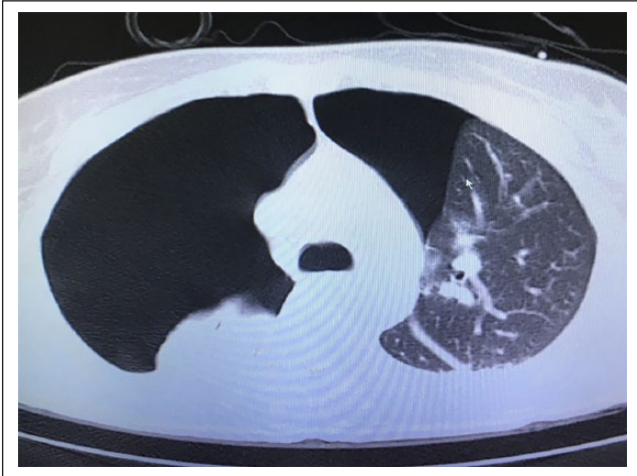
CT scan with right massive pneumothorax and left pneumothorax.
